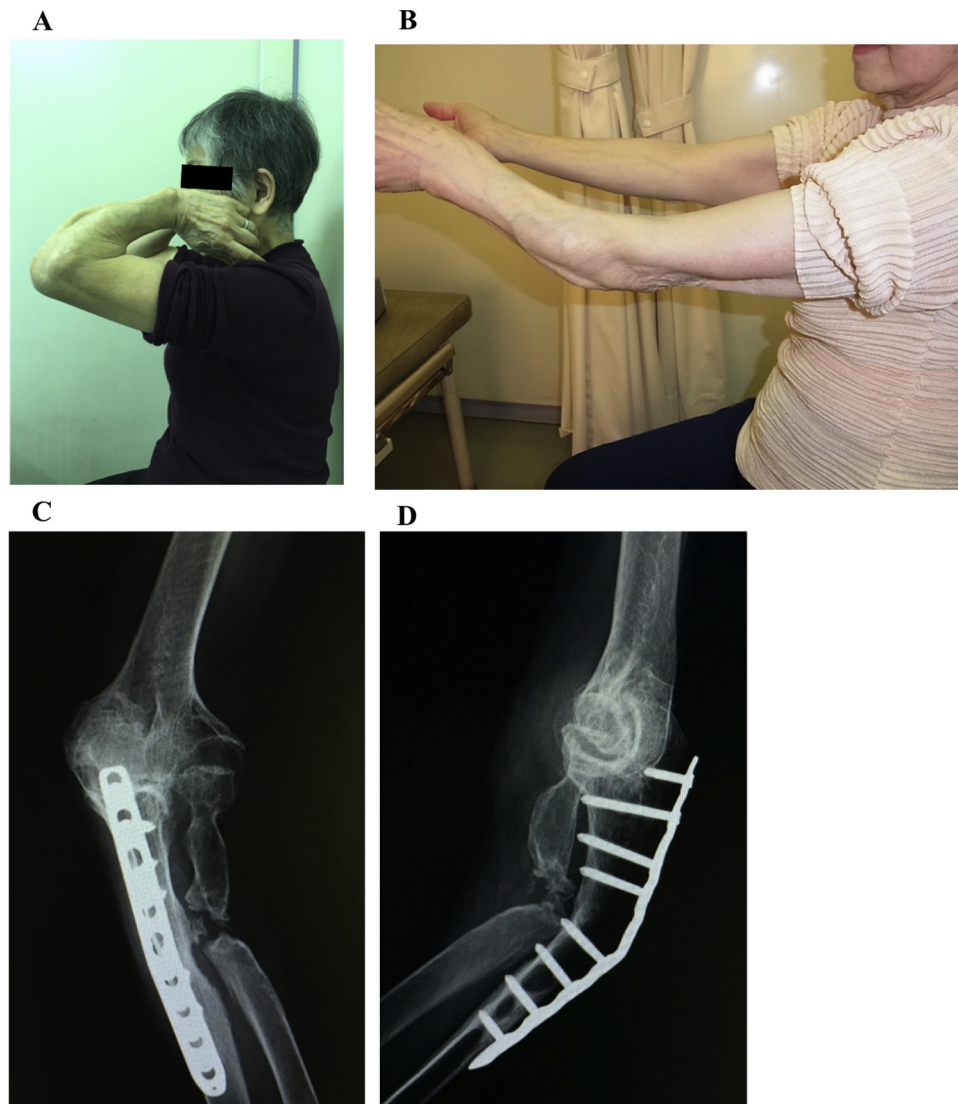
Postoperative outcomes at 7 years follow-up. A: The range of motion of the left elbow was 135° for flexion at 7 years follow-up. B: The range of motion of the left elbow was -30° for extension at 7 years follow-up. C: The radiographic frontal view of forearm and elbow at 7 years follow-up. D: The radiographic lateral view of forearm and elbow at 7 years follow-up.
